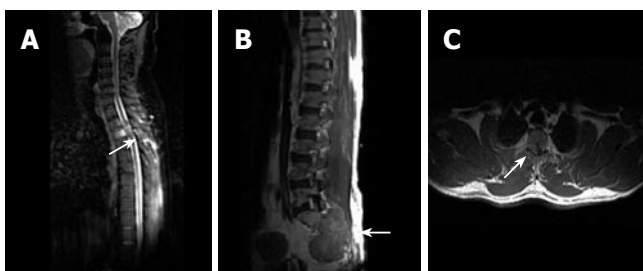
A: Sagittal MR image of cervicodorsal spine showing vertebral lesions with most prominent D3 vertebral lesion (arrow); B: Post contrast sagittal T1W SE MR image of the same patient showing lesion involving S2, S3 vertebrae (arrow) with associated large soft tissue component; C: T1W SE axial post contrast MR image showing right lateral epidural soft issue enhancing component (arrow) causing cord compression.
